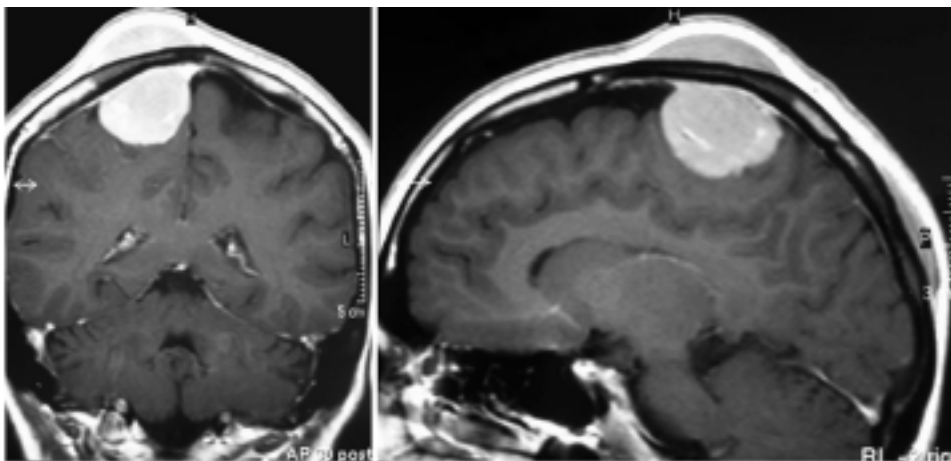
Coronal (*left*) and sagittal (*right*) Gd-enhanced T₁-weighted MR images showing a homogeneously enhancing EC–IC right parietal mass with invasion of the sensory cortex and a small subgaleal lesion in the occipital region.
